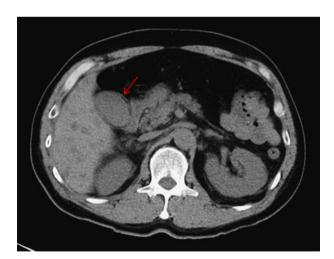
An enhanced abdominal CT scan showing dilatation of the gallbladder with a thick gallbladder wall (arrow).
